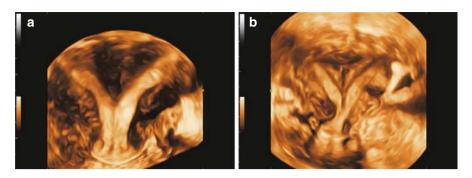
(a) Coronal view of the endometrium in an incomplete bicornuate uterus on 3D ultrasound, showing a "Y-shaped" endometrium. (b) Coronal view of the endometrium in a complete bicornuate uterus on 3D ultrasound, showing a "V-shaped" endometrium
